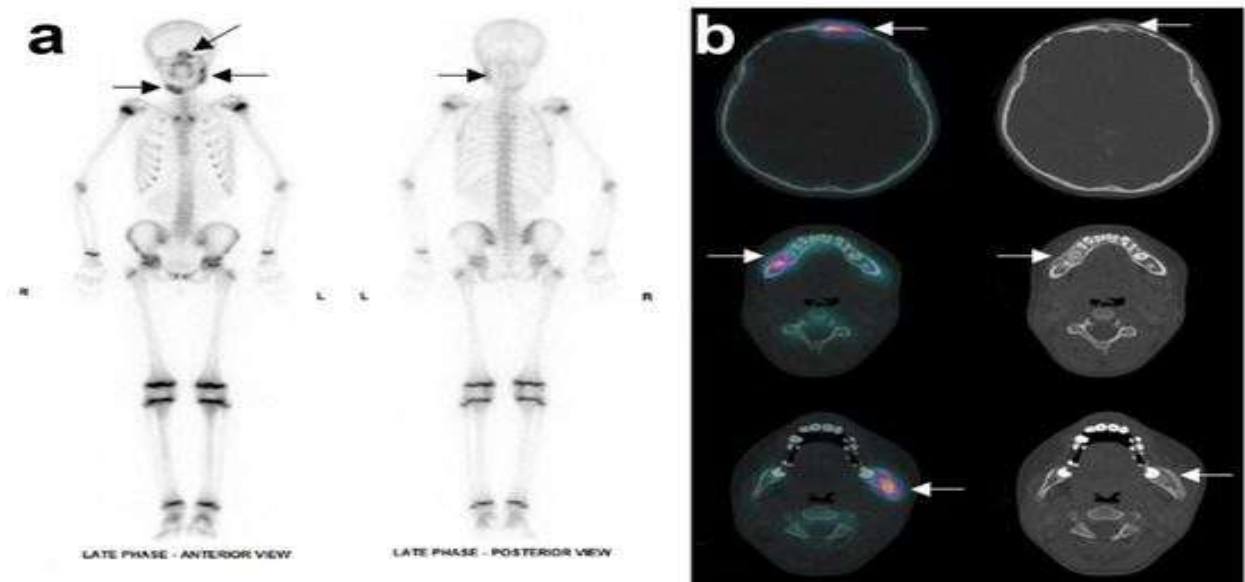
Nuclear X-ray of the patient's initial state: (a) Whole-body bone scintigraphy showed three areas of increased uptake (hot spot) in the facial skeleton: in the body of the right mandible, in the angle and ascending ramus of the left mandible, and in right frontal sinus. (b) SPECT registered with CT scan displaying, from top to bottom line, the increased
